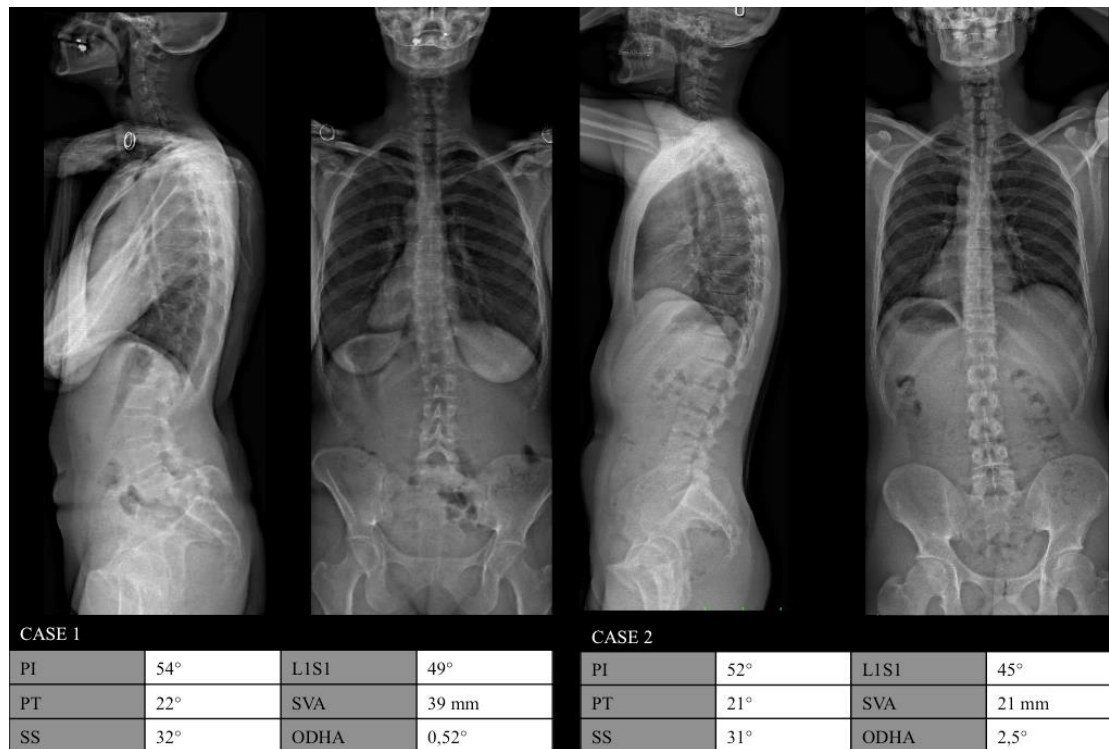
Full spinal EOS X-rays of two subjects with the same pelvic and global parameters. Case 1: A patient with L5S1 spondylolisthesis and severe lumbosacral kyphosis. Case 2: A volunteer without vertebral abnormalities.
